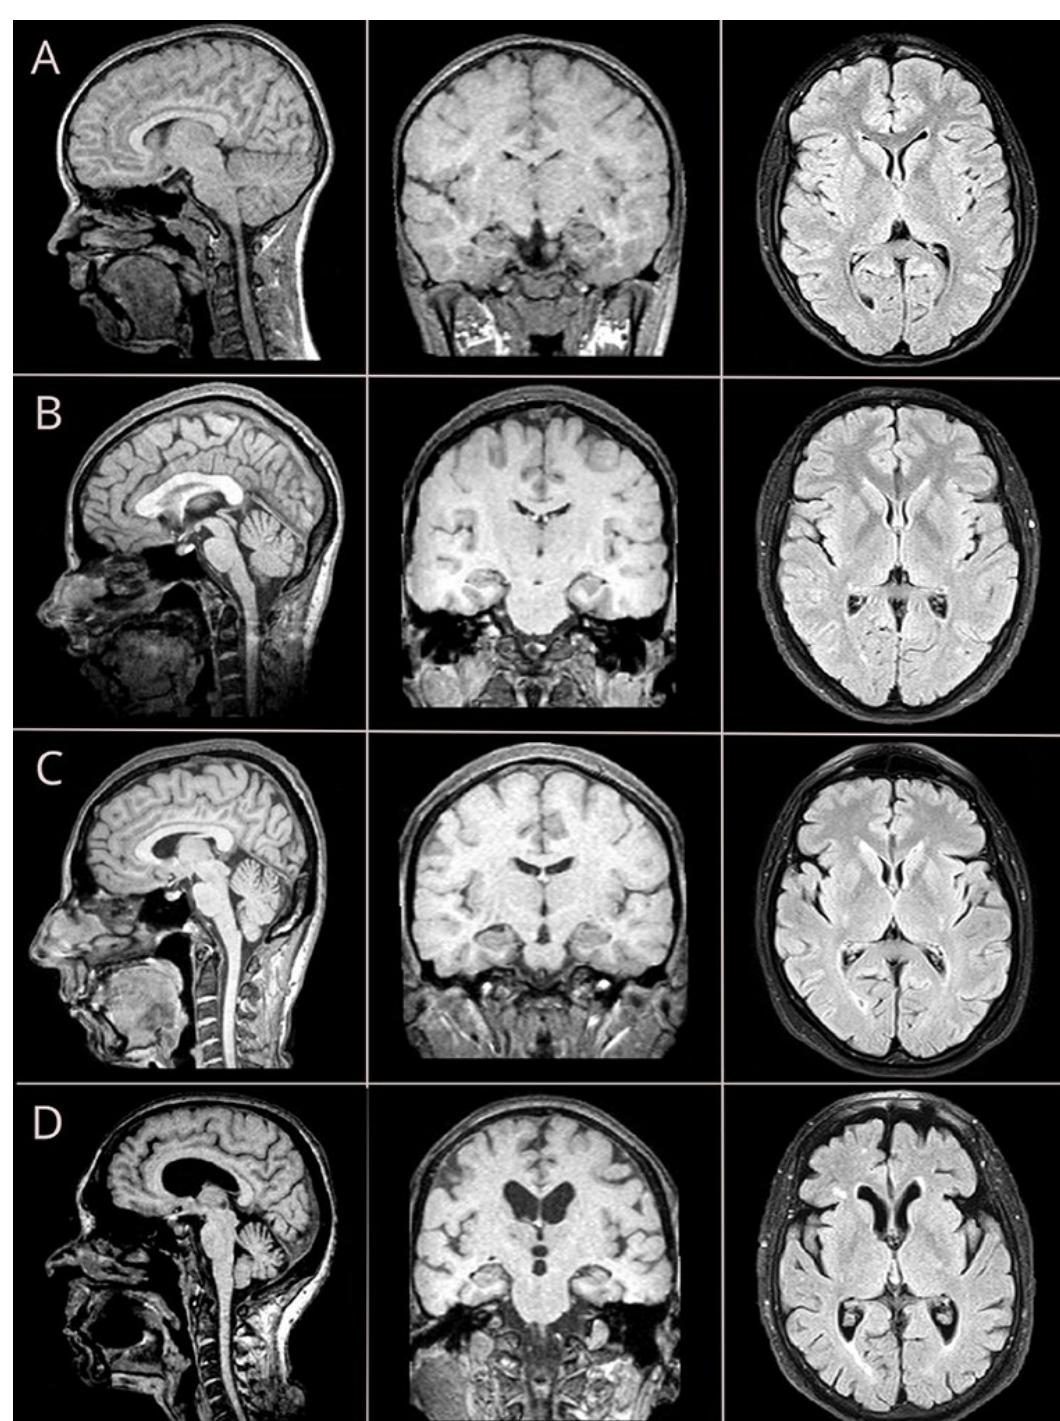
Brain MRI changes across adolescence (A), young adulthood (B), midlife age (C), and older adulthood (D).^[3]
